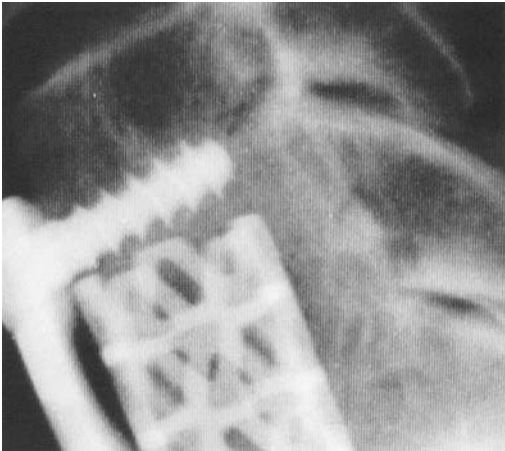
Two year postoperatively radiography of the same patient as in [Fig. 34](#), revealing remodeling of host implant interface and apparent arthrodesis.
